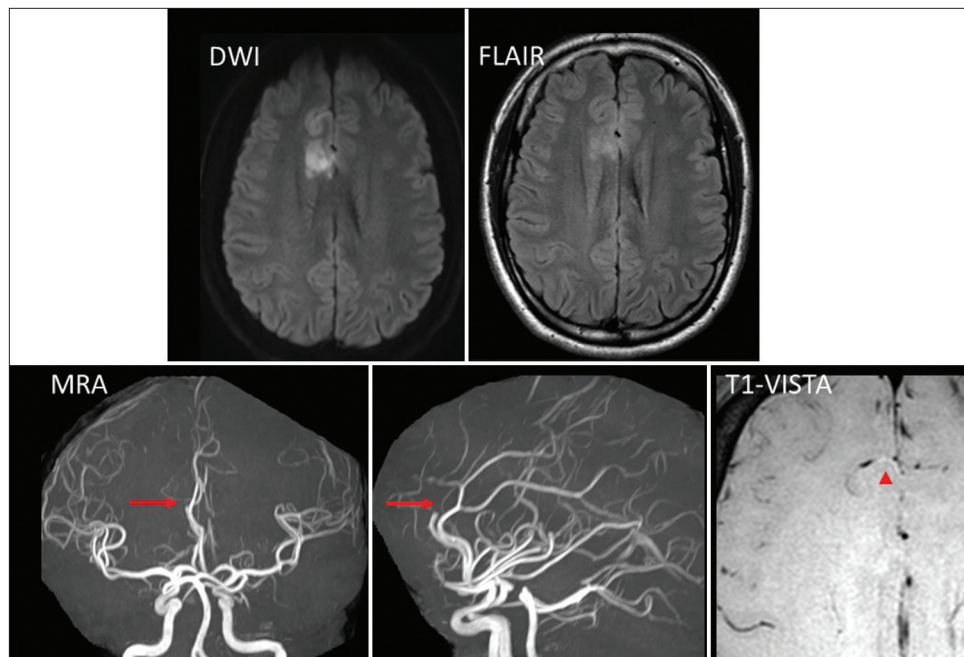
Head magnetic resonance imaging and magnetic resonance angiography (MRA) on admission diffusion-weighted imaging and fluid-attenuated inversion recovery showing acute cerebral infarction in the medial right frontal lobe, MRA showing occlusion of the right anterior cerebral artery (\rightarrow) and T1-volume isotropic turbo spin-echo acquisition (T1-VISTA) showing an intramural hematoma with high signal intensity consistent with the occluded vessel (\blacktriangle). Red arrows indicate the occluded right anterior cerebral artery. Red arrowhead indicates intramural hematoma. DWI ; diffusion weighted image, FLAIR ; fluid attenuated inversion recovery.
